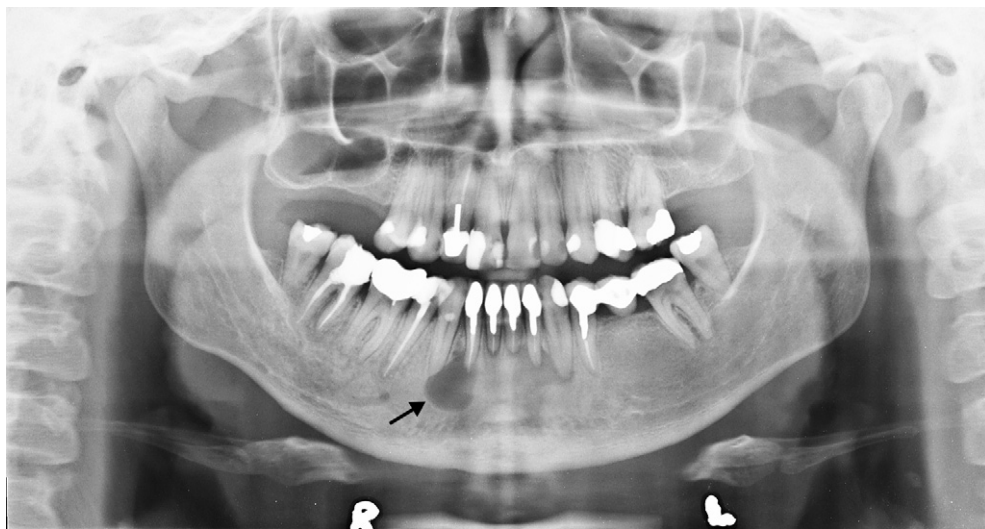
Large, periapical cyst associated with restored lower anterior teeth in a 44-year-old man. A well-outlined radiolucency extends from the periapical tissue of 42 across the midline to 33. Note the root treated 32–42 teeth.
